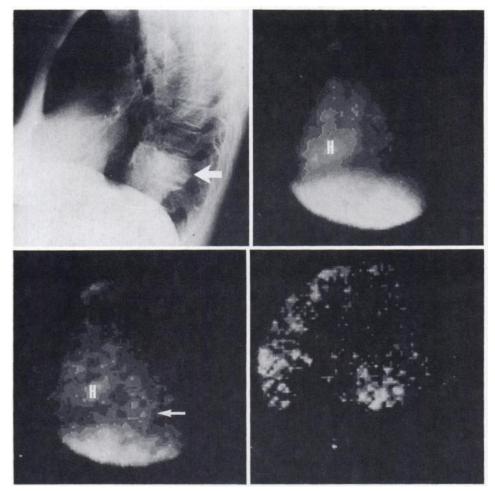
Female patient, age 60, with left-lung metastasis from previously resected colon carcinoma. Left lateral views. Chest radiograph (upper left) shows large mass behind heart (arrow). Tc-99m red-blood-cell image (upper right) shows no focal uptake behind heart. I-131-labeled 17-1A image at 5 days after radioantibody injection (lower left) demonstrates increased focal uptake behind heart corresponding to mass (arrow). Subtracted image (lower right) enhances contrast of uptake in metastasis. H = heart; L = liver.
